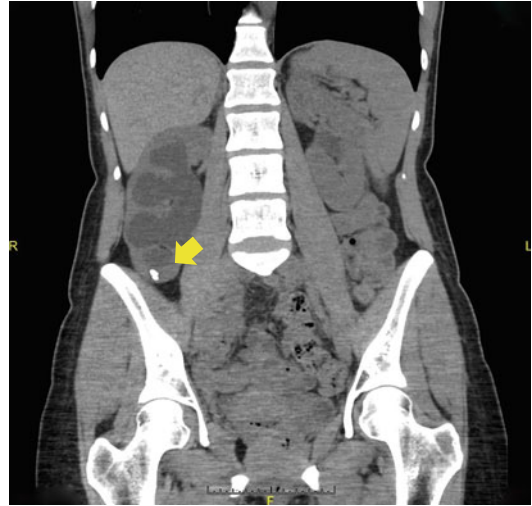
Coronal CT scan image demonstrating a right renal stone (yellow arrow) in a lower pole diverticulum
